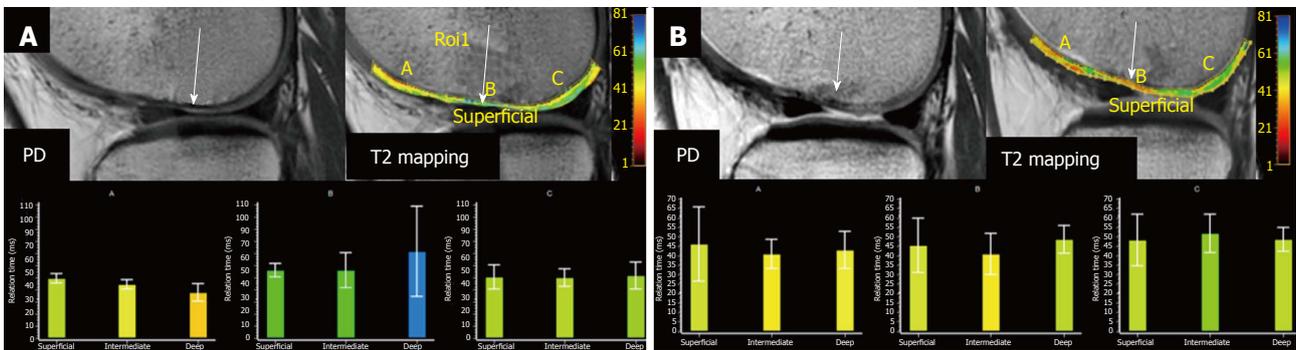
Treatment monitoring with magnetic resonance imaging in a 26-year-old gymnast with knee pain. Initial MRI (A) shows mild cartilage thinning at the medial femoral condyle with subchondral damage PD image. A moderate increase in T2 relaxation values (arrow) confirms the loss of collagen fibers in this area. Patient underwent MTX therapy and a follow-up MRI performed 3 mo later (B) demonstrates moderate chondral irregularity with focal areas of increased signal intensity on PD. T2 mapping demonstrates normalization of T2 relaxation time values compared with the pre-treatment study due to the generation of new fibrous cartilage. MRI: Magnetic resonance imaging; MTX: Microfracturing therapy; PD: Proton-density images.
